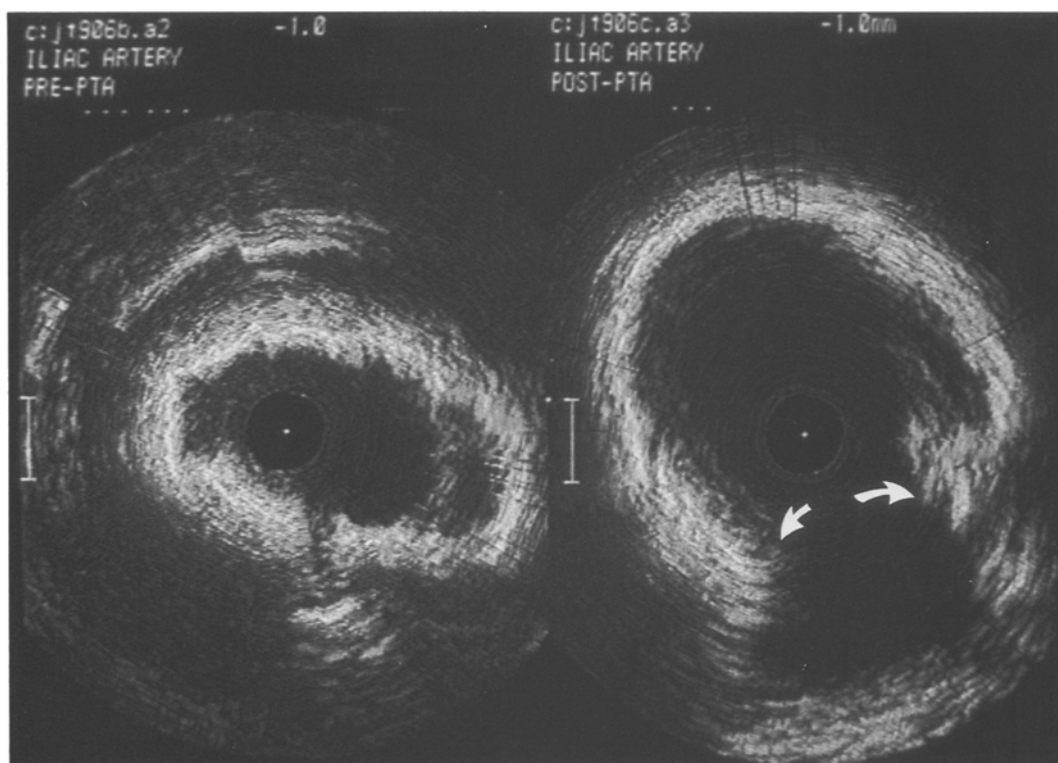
Pair of ultrasound images obtained from the arterial segment shown in Fig. 1. In the ultrasound image prior to balloon angioplasty (left), although the outline of the internal lumen is well demarcated, extensive fibrosis and calcification present within the plaque strongly reflected the ultrasound waves and prevented visualization of much of the media and adventitia layers. Following balloon dilatation (right), the lumen has increased substantially in area, primarily due to separation of the torn ends of the plaque (arrows). (Reprinted with American Heart Association's permission.)
